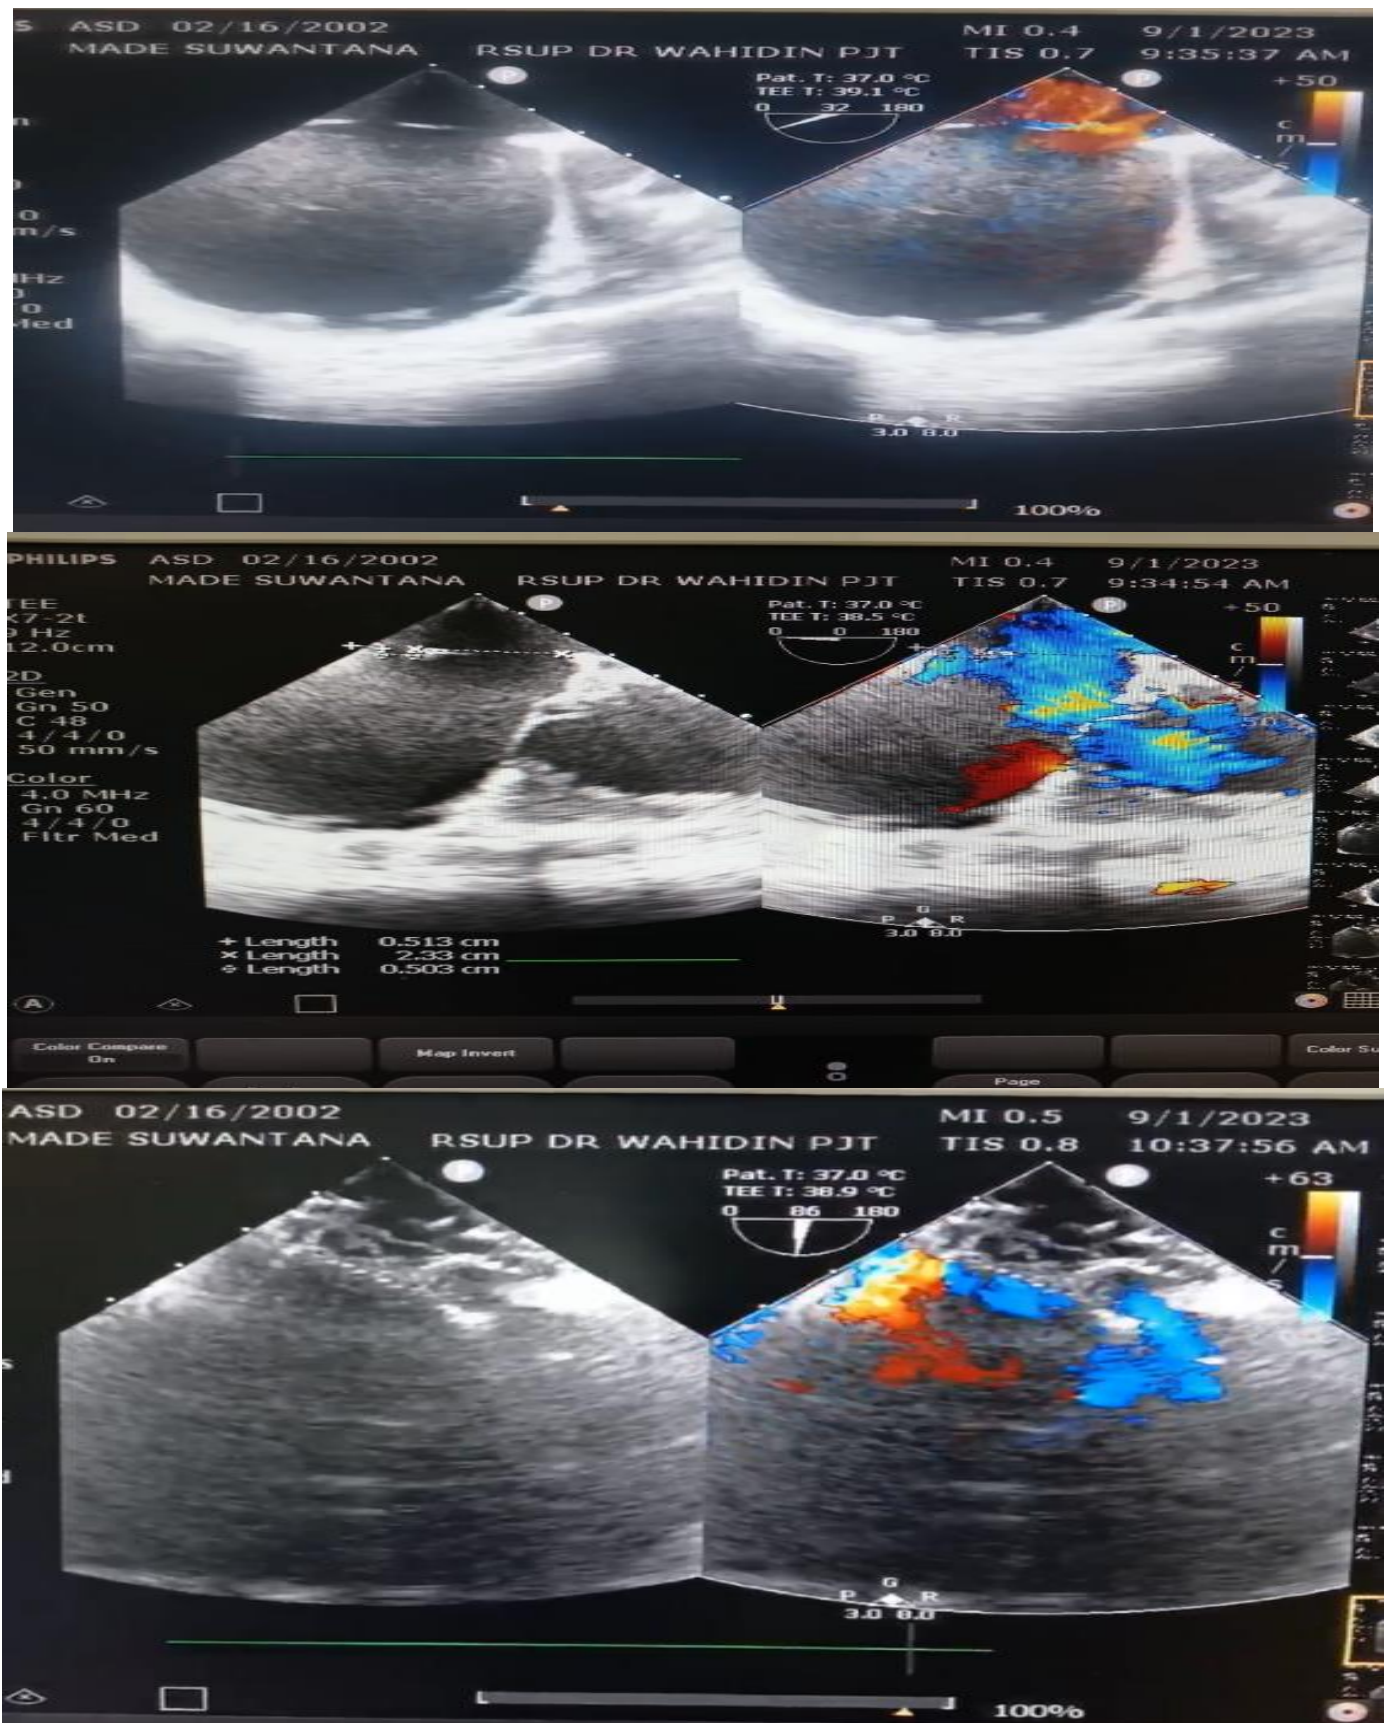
Transesophageal Echocardiography (TEE) and TEE Guiding Device Closure
